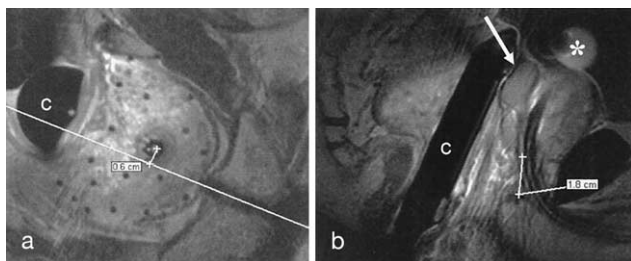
Evaluation of anatomy. (a) Measurement of prostate shift in left lateral decubitus position was accomplished by evaluating shift of urethra relative to bony pelvis. (b) Penile bulb to prostatic apex distance was measured on sagittal magnetic resonance imaging. Note that patient's utricular cyst (asterisk) was clearly visible on magnetic resonance imaging. C = endorectal coil.
